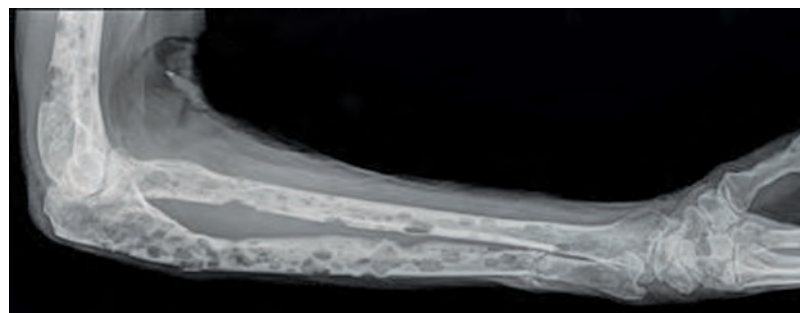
Multiple myeloma (X-ray)—extensive bone destruction caused by disease.
